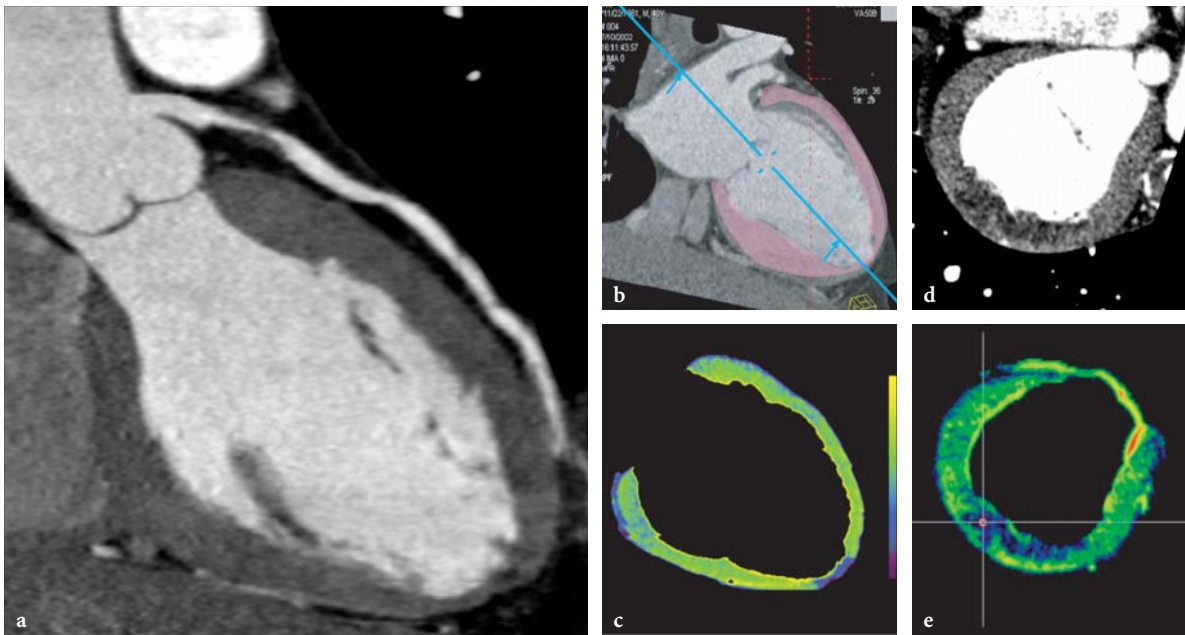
Evaluation of myocardial enhancement in a patient with suspected myocardial infarction, based on scan data acquired on a 64-slice CT scanner with 64×0.6 -mm slices per rotation. a MIP reconstruction reveals a high-grade stenosis in the proximal LAD. b, c Automated segmentation of the myocardium allows the generation of a color-coded map using a work-in-progress software. Short-axis reformation allows for the evaluation of first-pass myocardial perfusion defects. d While the corresponding hypo-attenuated area in the myocardium can also be appreciated in the original MPR, e segmentation of the blood pool and color-coding facilitates (blue color for low perfusion) the diagnosis. (Case courtesy of Hôpital Marie Lannelongue, Paris, France)
